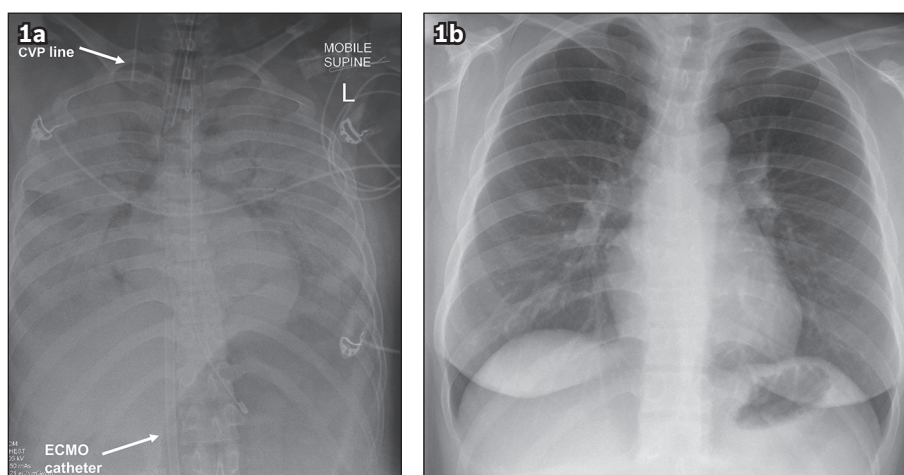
Chest radiographs show (a) bilateral 'white-out' lungs from extensive consolidation at presentation to the emergency department; and (b) complete resolution of the radiological abnormalities six weeks later. CVP: central venous pressure; ECMO: extracorporeal membrane oxygenation
